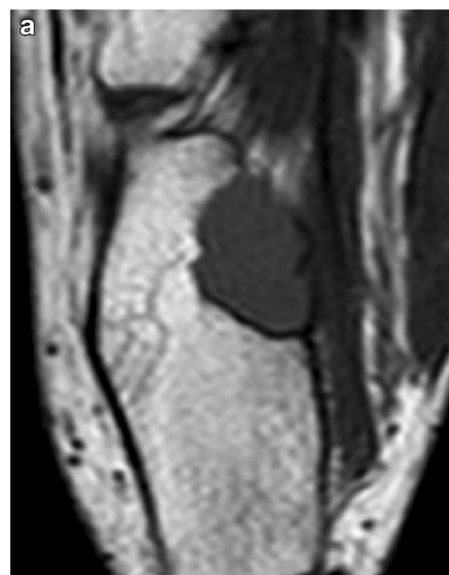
Recap of the progression on axial T1-weighted MRI. The lesion displays low signal intensity on initial examination (a). Some 4 years later, high signal intensity appears in the peripheral portion of the lesion (arrow in b). Then, 7 years after the initial examination, most of the lesion displays high signal intensity on T1 weighting (c) similar to the signal of subcutaneous or medullary fat
